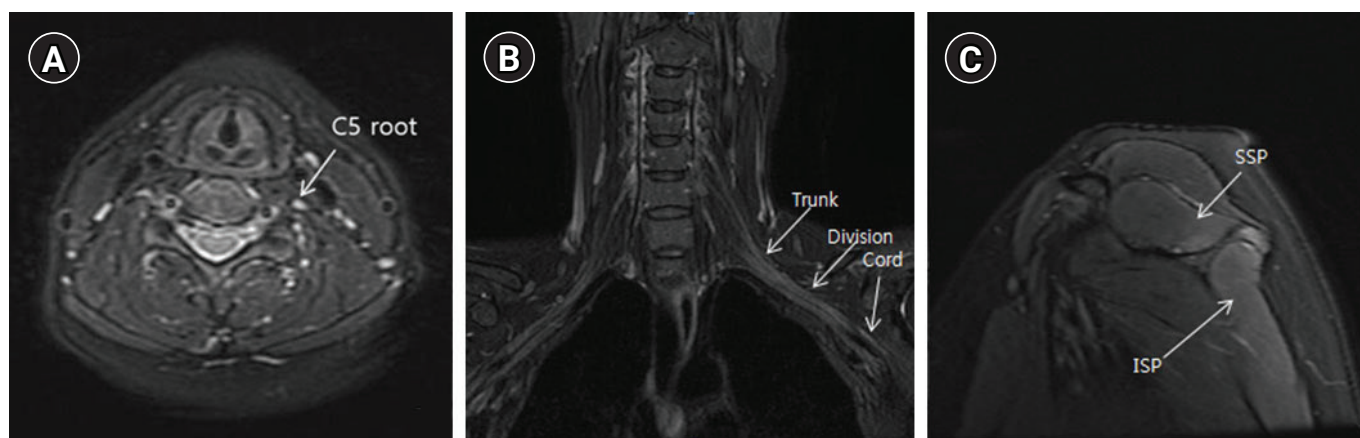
Brachial plexus MRI with contrast enhancement for a patient with BPN. A) T2 water-excited sagittal image: mild nodular swelling observed in the post-ganglionic level of the C5 nerve root; B) T2 water-excited coronal image: swelling and high signal intensity observed in the left trunks, divisions, and lateral cord; C) T2 water-excited sagittal image: mild-high signal intensity in the left supraspinatus (SSP) and infraspinatus (ISP), suggesting a denervation change related to the suprascapular nerve.
